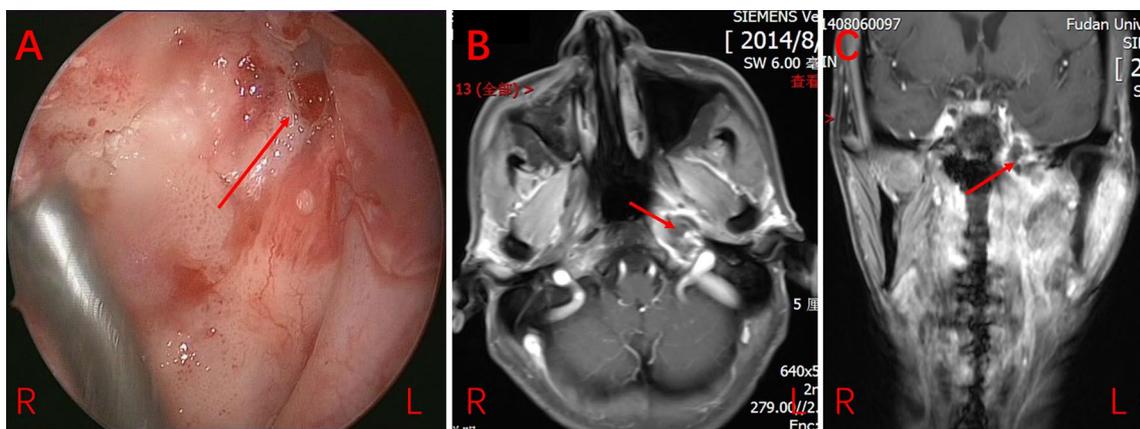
a The endoscopic examination of one patient with skull base ORN which did not show the necrotic tissues. b, c The necrotic tissues by contrast-enhanced MRI
